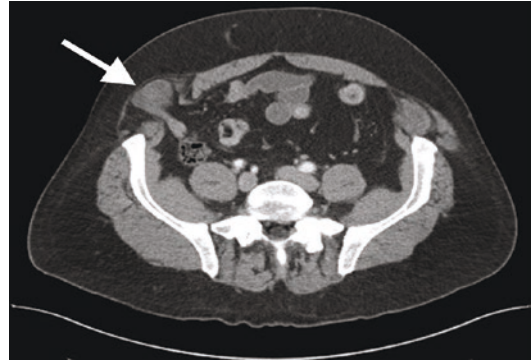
CT scan of a right Spigelian hernia causing a partial small bowel obstruction. The hernia was reduced at the bedside and the patient underwent a semi-elective minimally invasive hernia repair with mesh
